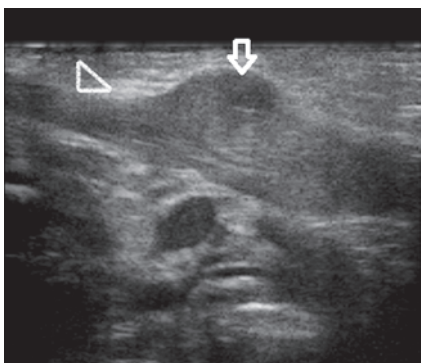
Ultrasound neck- Sternomastoid tumor (arrow) with normal muscle thickness (arrow-head)
